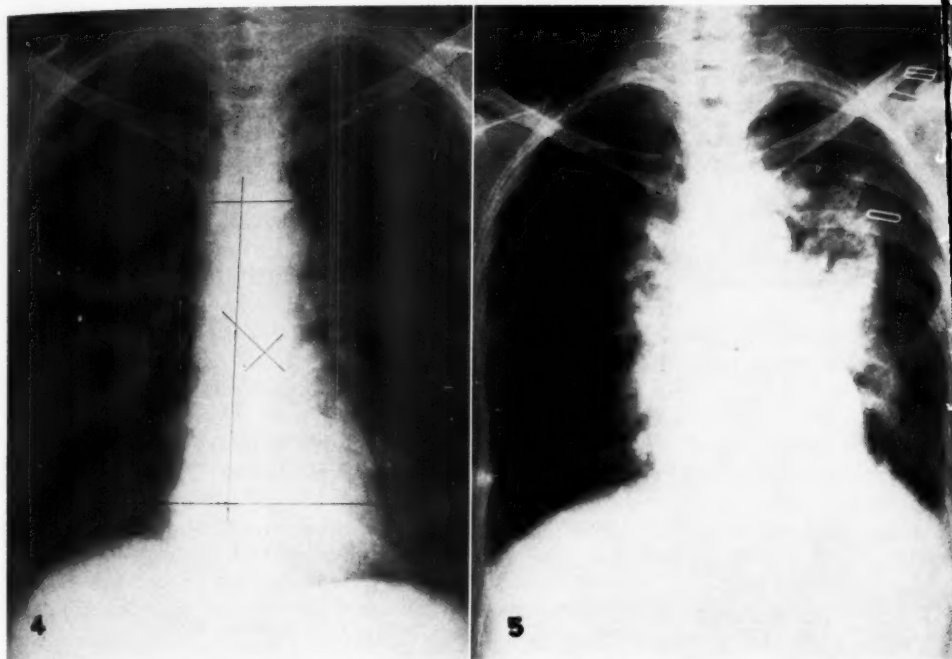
Roentgenogram of the chest demonstrating a tumor in the left hilus and left lower lobe with questionable tumor in the right hilar area. The lines drawn on the film show the limits of a 15 X 15-cm. field.
